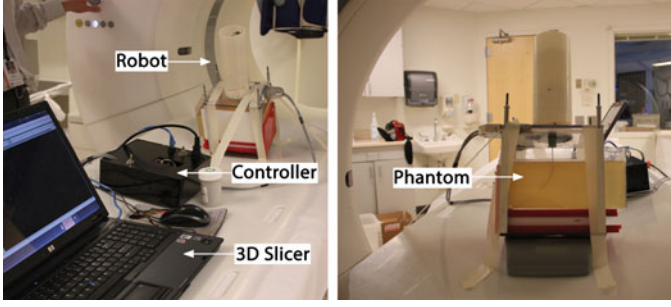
Robot, positioned with some arbitrary angles on the CT scanner bed, ready to move inside the bore for preprocedural imaging. A laptop computer was connected via the Ethernet to 3-D Slicer where the graphical user interface, the robot kinematics, and the registration were developed and integrated into the new IGT module.
